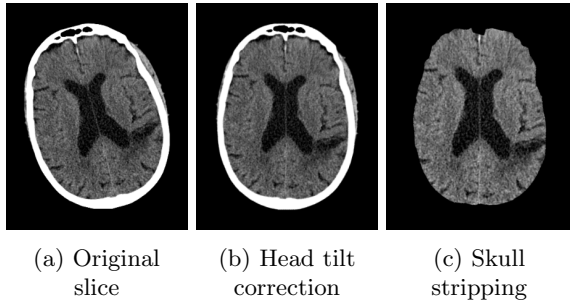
Main steps in CT images processing.
